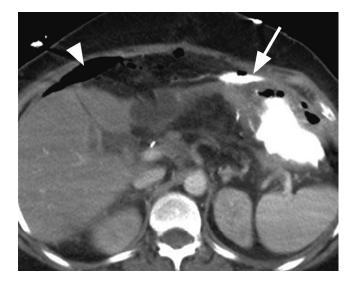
Axial computed tomography image of the abdomen with contrast showing extraluminal contrast in the peritoneum anterior to the stomach compatible with leak (arrow). Free air is seen (arrowhead).
